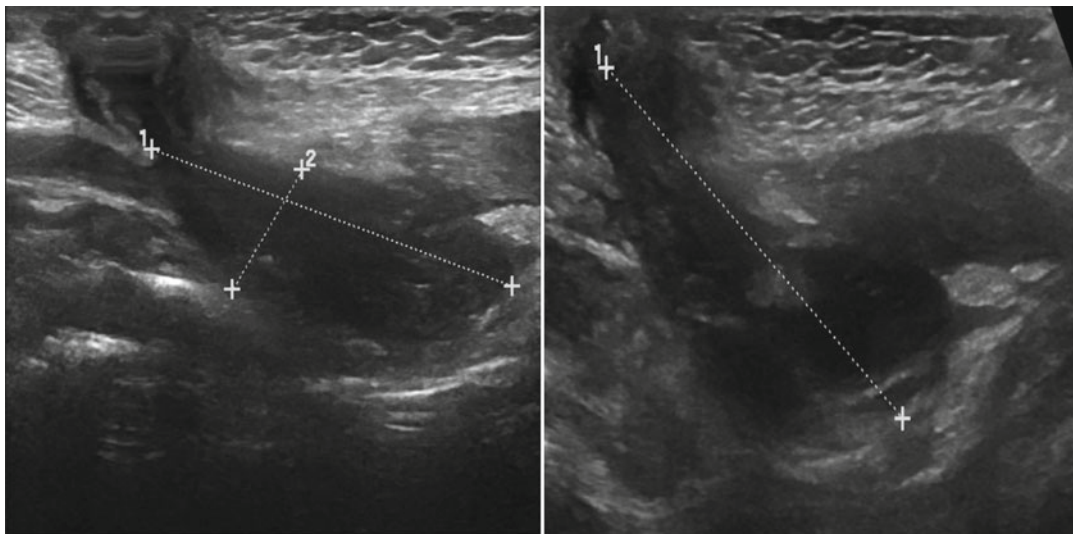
Ultrasound shows a urachal sinus abscess: hypodense collection that is projected along the central line, in continuity with the umbilical scar
